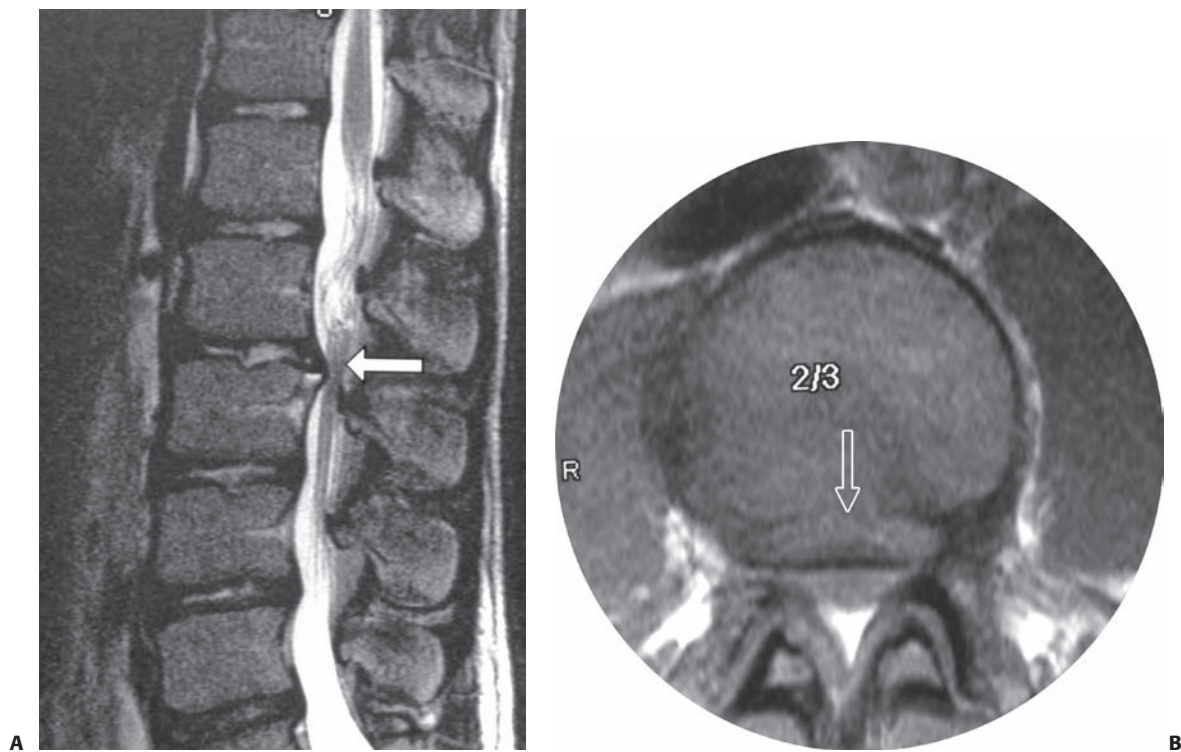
Ring apophyseal avulsion injuries. A: This lateral MRI image demonstrates displacement of the ring apophysis, which functionally acts as a disc herniation. This, however, represents largely a bony and cartilaginous fragment, which results in neural element compression. B: Transverse image demonstrating canal stenosis associated with this injury.
